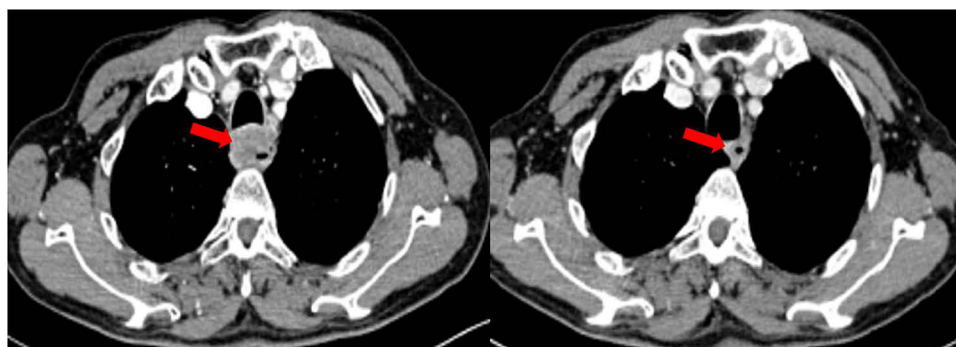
CT scan results of the changes for target lesions in the primary esophagus site of a male patient with metastatic ESCC before and after the treatment using tislelizumab (red arrows indicated the locations of the target lesions).
